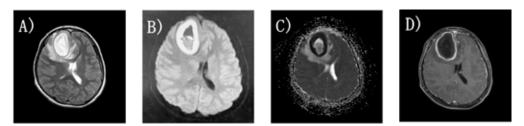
Contrast head MRI examination at admission
